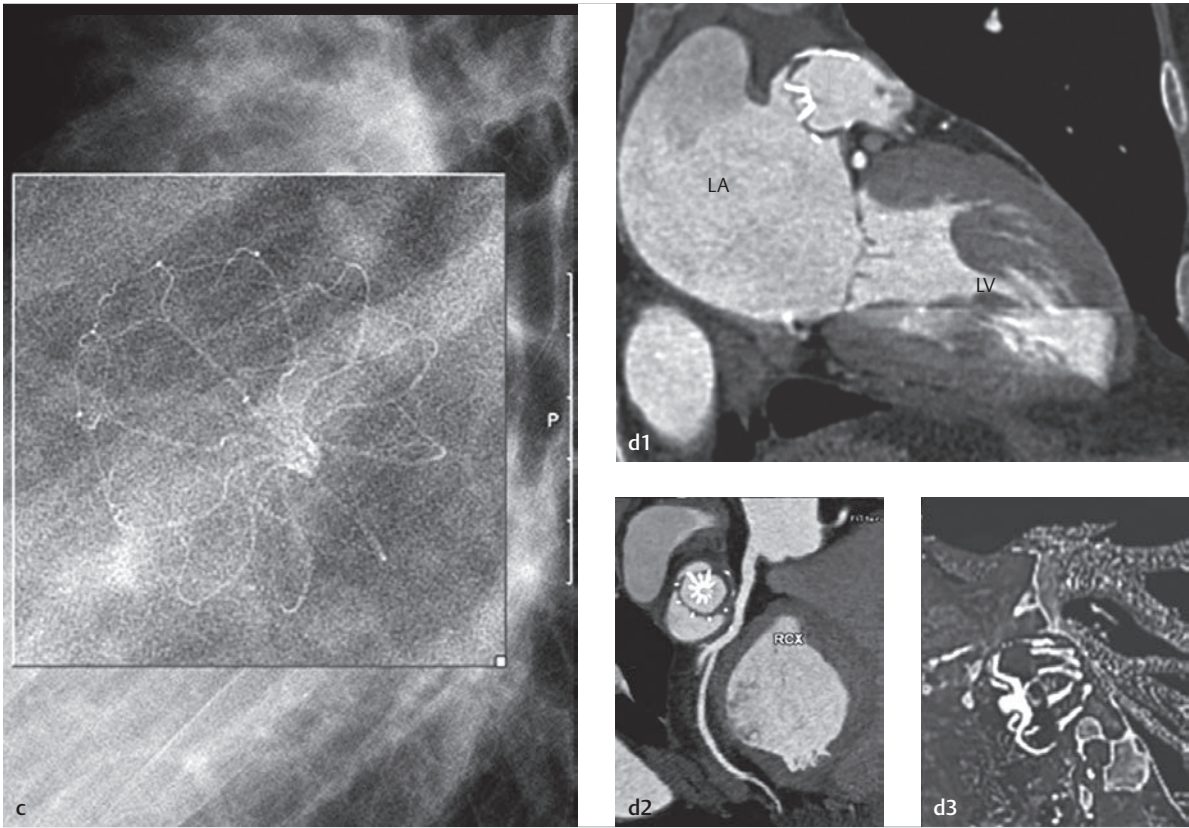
(Continued) Combination of angiography, X-ray, and CT with echocardiographical methods. Simultaneous angiographic and echo depictions of a Watchman closure device in the left auricle of a male patient with chronic atrial flutter and contraindication against oral anticoagulants.
